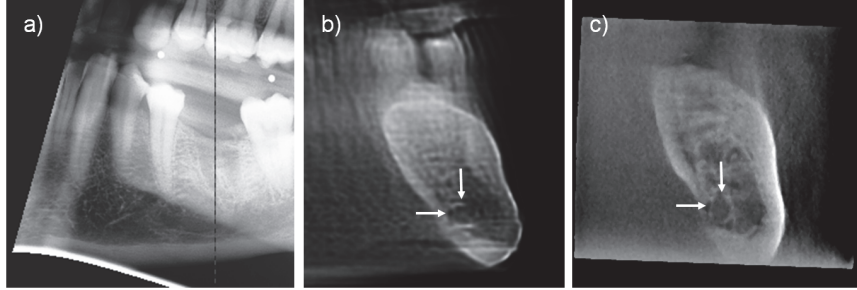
a) Panoramic image, where the position of the slice b) is highlighted. Reconstructions taken with a b) VT and c) CBCT device from the same location. The mandibular nerve is highlighted in both images. The VT slice is generated with 11 projection images while in CBCT number of the images is over 300. Regardless of VT slice includes more artifacts, the mandibular nerve is clearly visible in all images.
